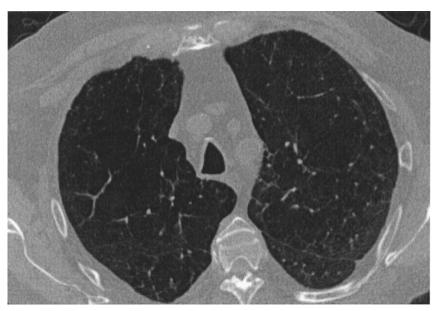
Chest CT scan of a patient with COPD.
